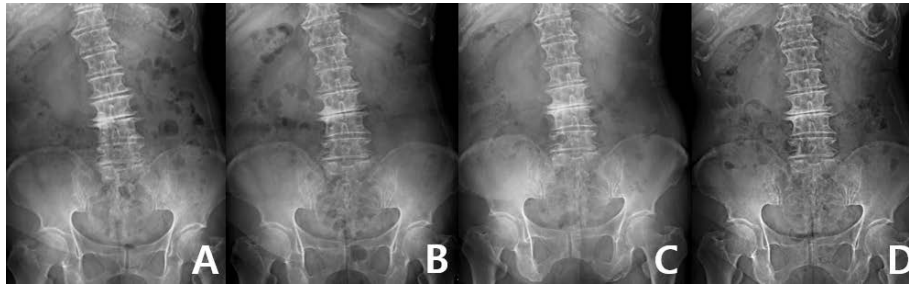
The change of scoliosis observed on the radiographs. (A) Before treatment. (B-D) Progression during treatment. Before hospitalized treatment began, the inclination of the scoliosis was most steep. As the treatment progressed, the inclination gradually decreased, and was maintained.
